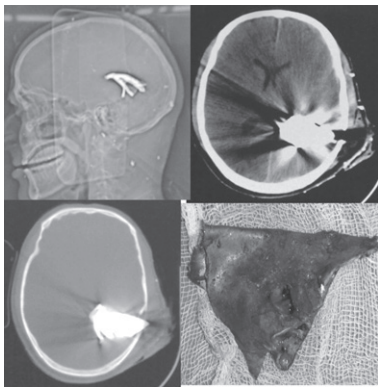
X-ray and plain CT head showing large metallic (steel) shrapnel of 70 mm length recovered from brain.
